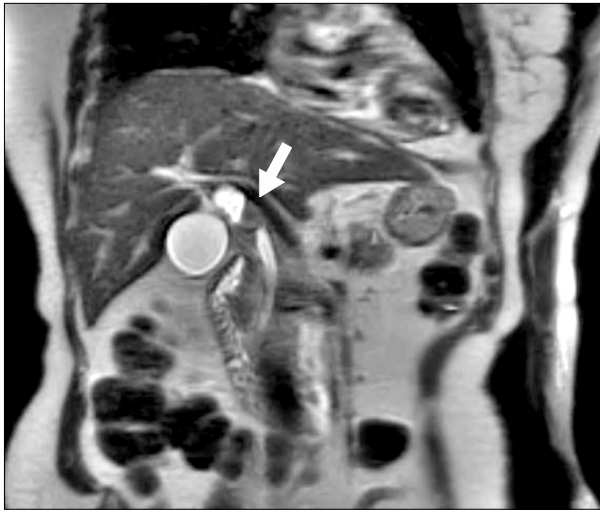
A coronal T2-weighted image of magnetic resonance revealed an exophytic intermediate hyperintense mass (arrow) in the extrahepatic bile duct.
